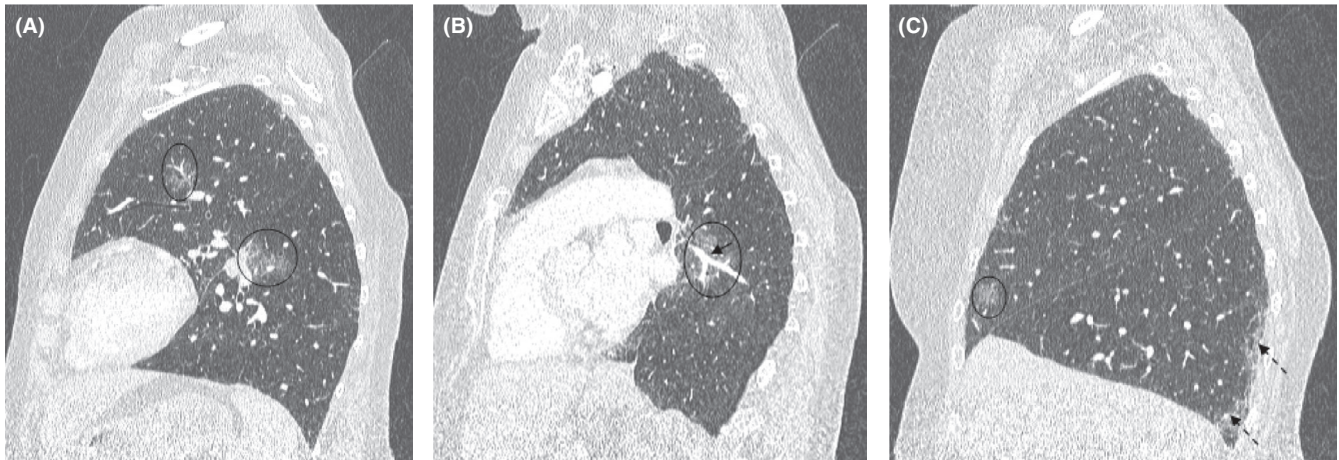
A-C, Sagittal chest CT images showing linear reticular subpleural opacities, multifocal, bilateral subpleural and peribronchovascular patchy and nodular ground-glass opacities, involving 5%-25% of the lung parenchyma with dilated vessels (Black arrow) in the affected areas
